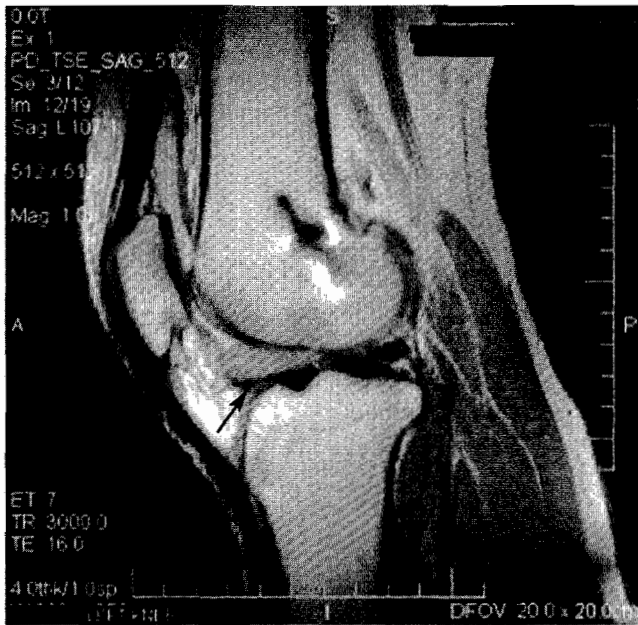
Sagittal MRI knee proton-density Cyclops lesion.
